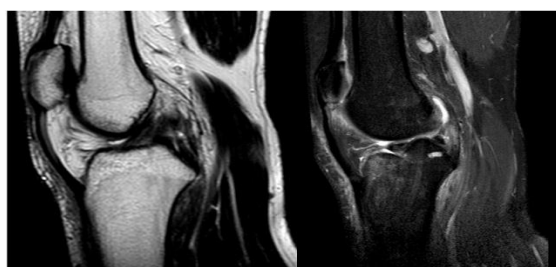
MRI Appearance of PCL Tear
